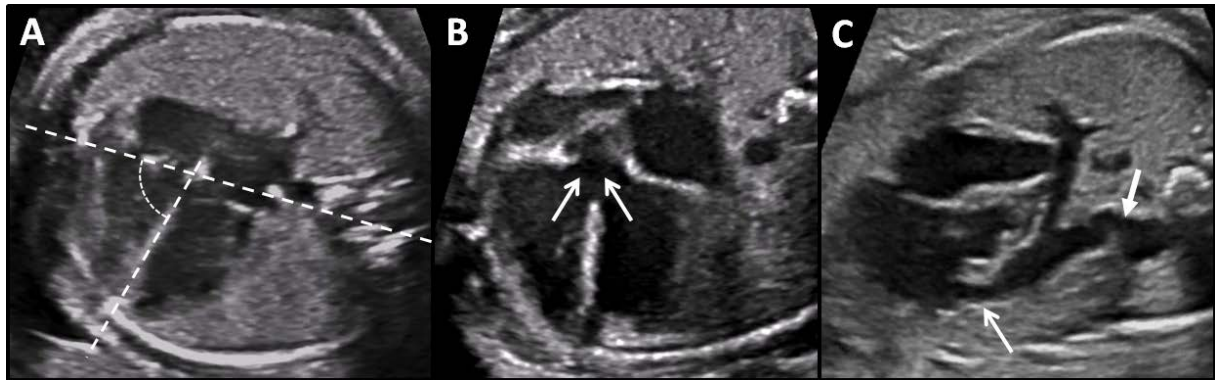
Typical sonographic features of fetal tetralogy of Fallot (TOF). A. Four-chamber view, increased cardiac angle. B. Aorta overriding the ventricular septal defect (arrows). C. Subvalvar right ventricular outflow tract obstruction (thin arrow), well developed pulmonary arteries and tortuous ductus arteriosus (thick arrow) in a fetus with TOF-pulmonary stenosis
